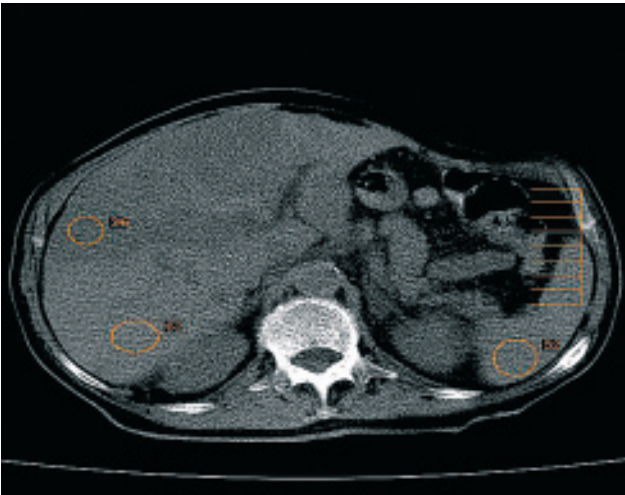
Non-contrast CT. The fatty liver appears hypodense (darker) as opposed to the splenic parenchyma and it also appears spotted (focal steatosis).
